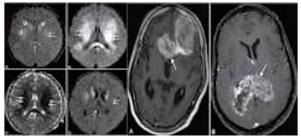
3 (a) and (b) MRI images of Perilesional oedema.
